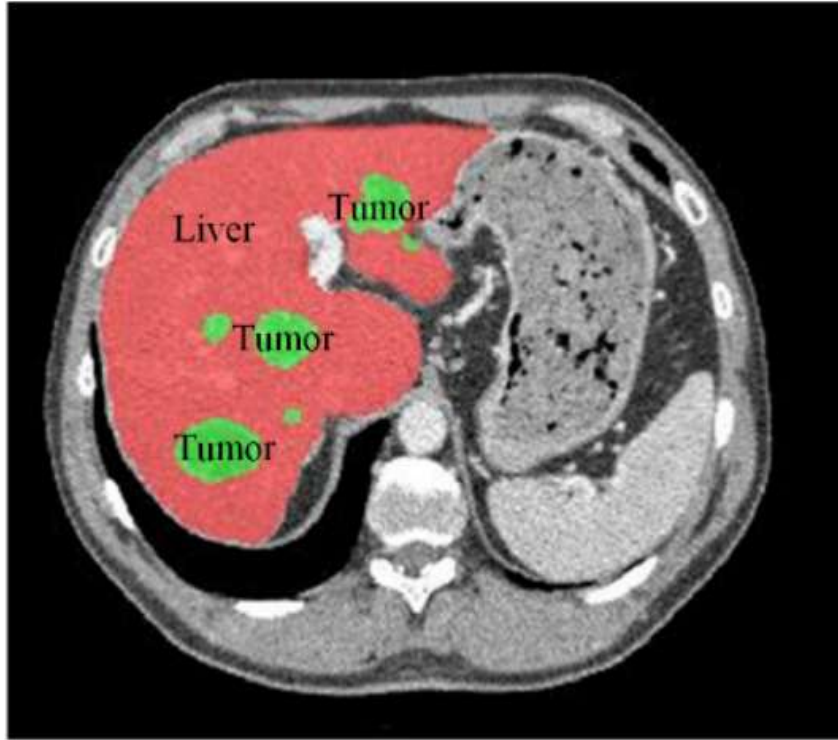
CT scan highlighting the liver and tumors in the abdominal region.
